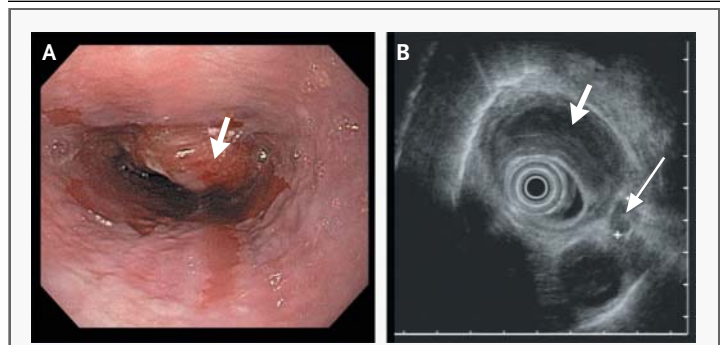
Endoscopic Image (Panel A) and Endoscopic Ultrasonogram (Panel B) Showing a Transmural Adenocarcinoma of the Esophagus Associated with Barrett's Esophagus (Short Arrows), with Lymph-Node Metastases (Long Arrow). Courtesy of John Saltzman, M.D.
